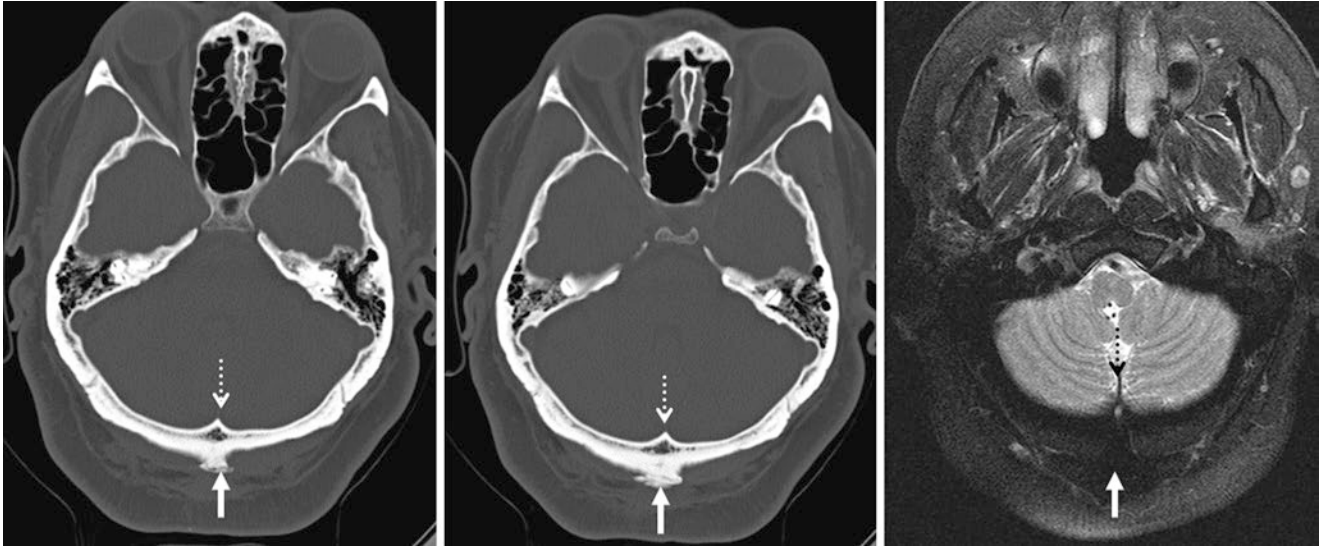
A 63 year old with an EOP (solid arrows) and IOP (dotted arrows) on axial NECT (left and middle) and T2WI MRI (right)
